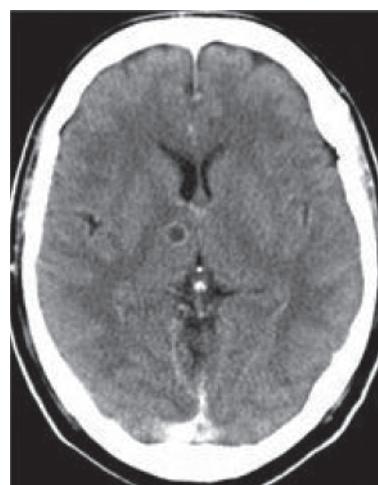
Enhanced axial CT brain demonstrating a small well defined rounded rim enhancing lesion at the right thalamus indicating a cerebral abscess.
